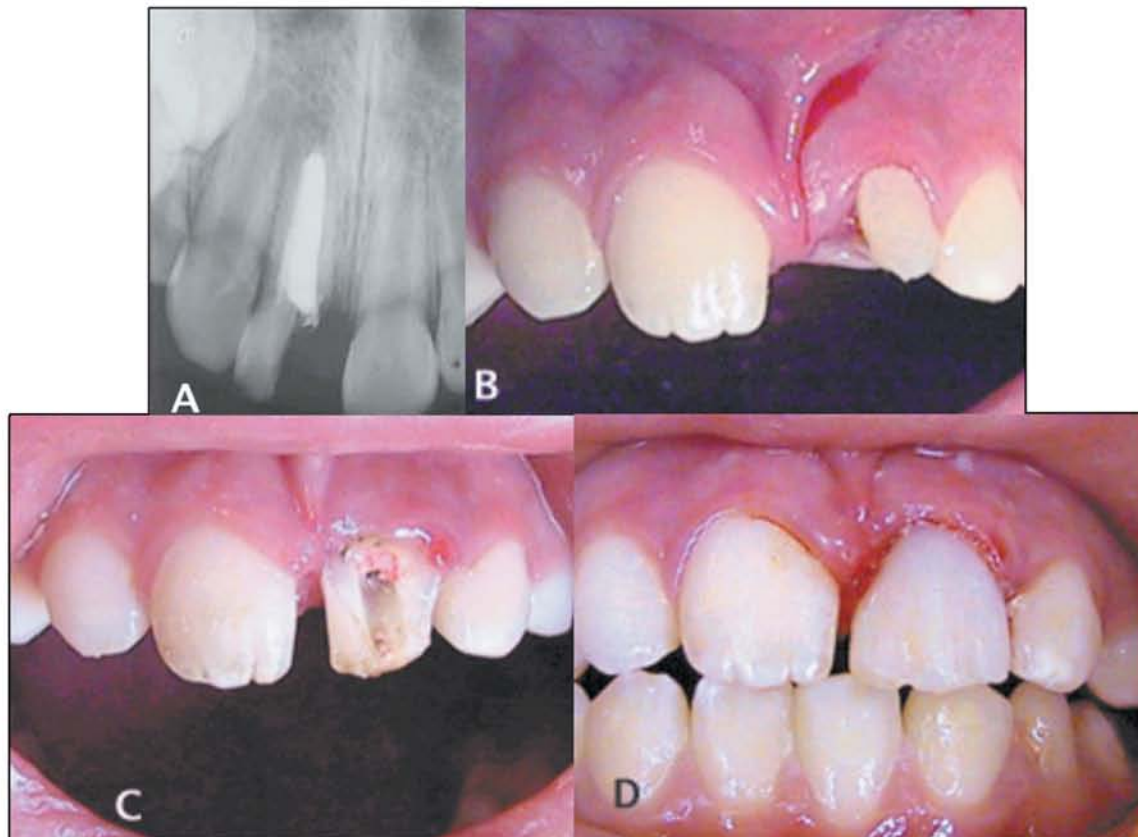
A complicated crown-root fracture on tooth 9 in a 10-year-old Afghanian boy. A and B. Radiographic and photographic of oblique crown- root fracture below the marginal bone mesial on tooth 9. C. The root is rotated 90 degree (mesial aspect at the labial aspect) and transplanted. D. After placement of the resin core builds up.
